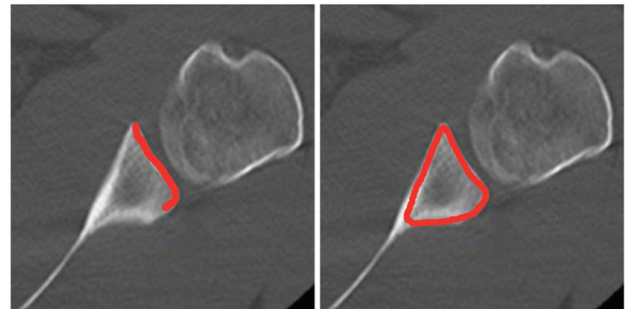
CT 显示后方肩盂发育呈 Lazy J 及 Δ 形状(红线所示)。表明后方肩盂发育不良
